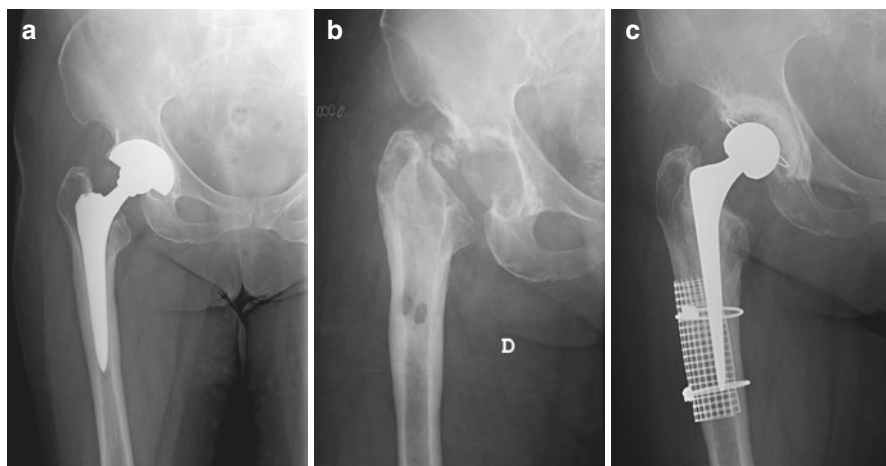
(a) Anteroposterior radiograph of the hip of a 70-year-old woman shows an infected cementless total hip arthroplasty. (b) Resection arthroplasty. (c). The hip was reconstructed using impacting bone grafting with cemented components., with a good clinical outcome at 5 years
